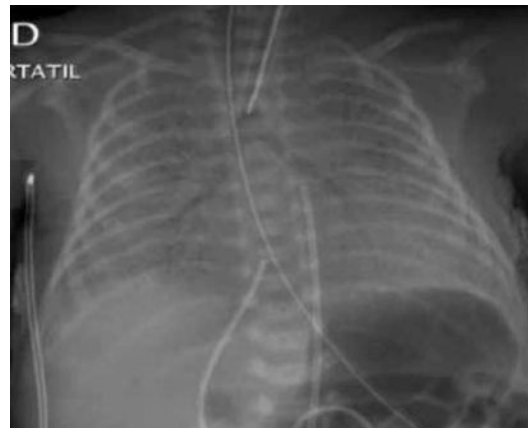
Hyaline membrane disease. Chest X-ray in newborn whose lung volume is lightly reduced (because the newborn has undergone intubation and receives positive pressure), frosted glass sign, and air bronchogram
